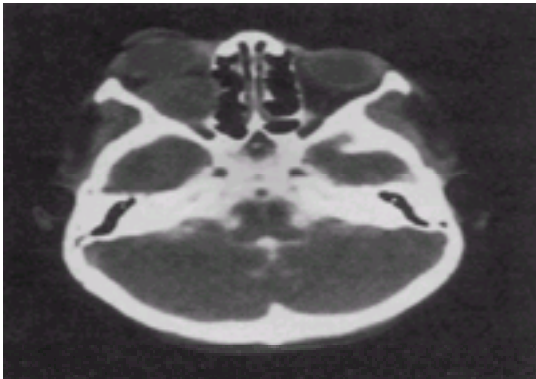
A 6-year-old boy developed proptosis of the right eye and decreased visual acuity. The CT scan showed a large soft tissue mass in the right orbit. Biopsy demonstrated embryonal rhabdomyosarcoma.
